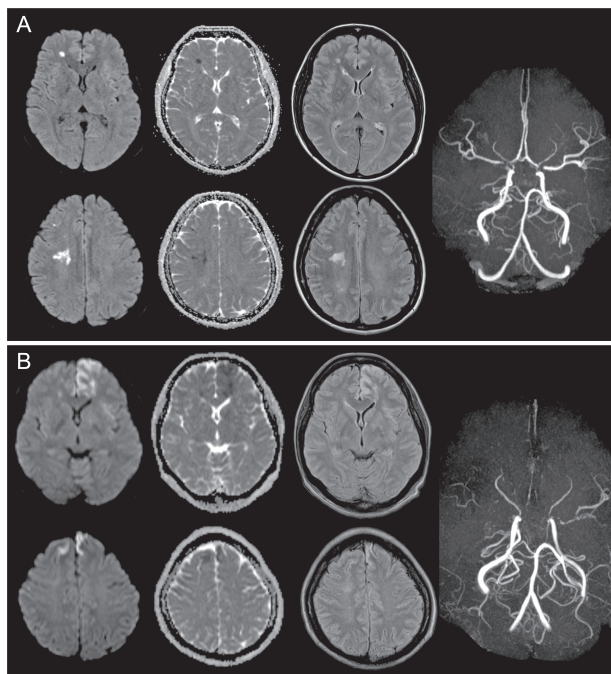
Preoperative magnetic resonance imaging including diffusion-weighted imaging, apparent diffusion coefficient maps, fluid-attenuated inversion recovery imaging, and magnetic resonance angiography (MRA)
